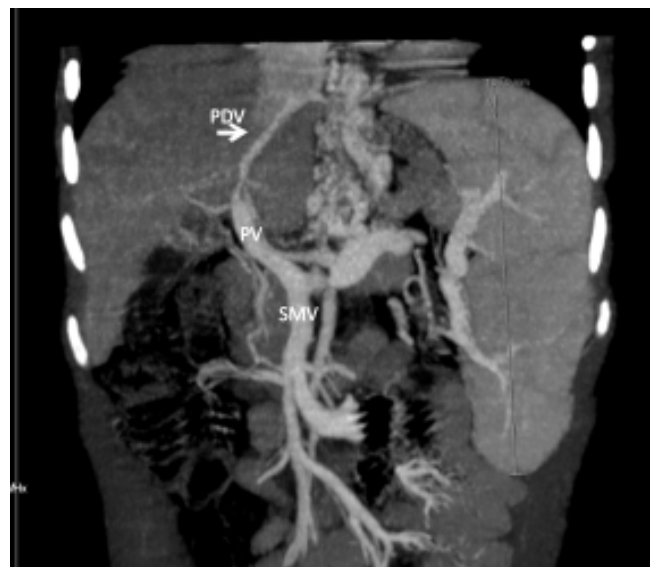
CT angiography of case 3 shows a patent ductus venosus (PDV) (arrow). PV: Portal vein. SMV: Superior mesenteric vein.
